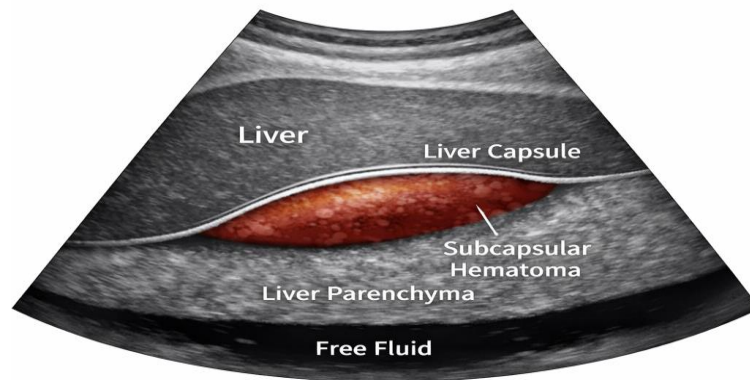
Abdominal ultrasound demonstrated a subcapsular hepatic collection measuring approximately 4 cm with heterogeneous echogenicity and no Doppler vascularization, associated with significant intraperitoneal effusion.
